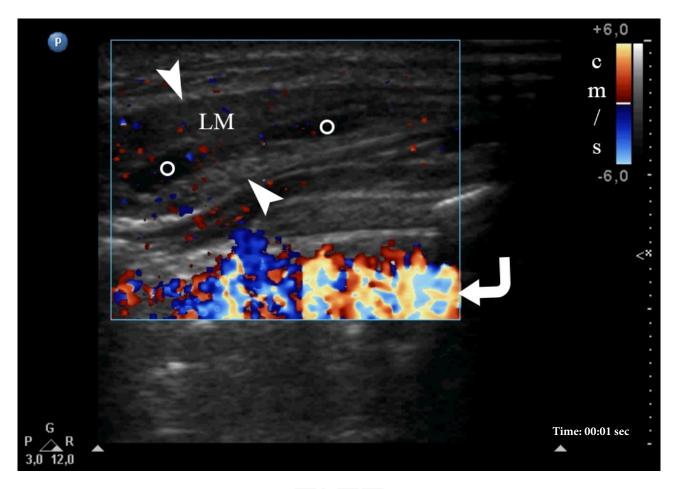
Color Doppler ultrasound of the left neck shows the relationship between the lymphatic malformation (LM), left sternocleidomastoid (SCM) muscle, and the main neurovascular structures of the neck (also known as neurovascular bundle of the neck). This neurovascular bundle (*open arrow*) is surrounded by carotid sheath which at different levels contains structures such as common and internal carotid artery, internal jugular vein, vagus nerve, etc. The letter "P" on a blue circle in the upper left corner of the sonogram indicates the probe's side.
